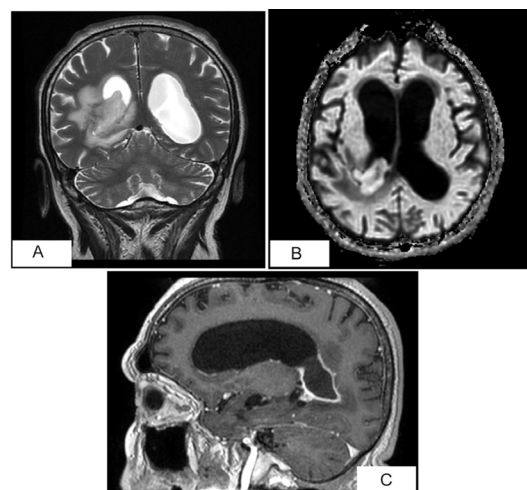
(A) MRI coronal plane demonstrating peritrial abscess and right posterior lateral ventriculitis. (B) MRI axial plane demonstrating peritrial abscess and right posterior lateral ventriculitis. (C) Another perspective of the peritrial abscess and right posterior lateral ventriculitis in MRI sagittal plane. (A–C) MRI demonstrating peritrial abscess and right posterior lateral ventriculitis.
